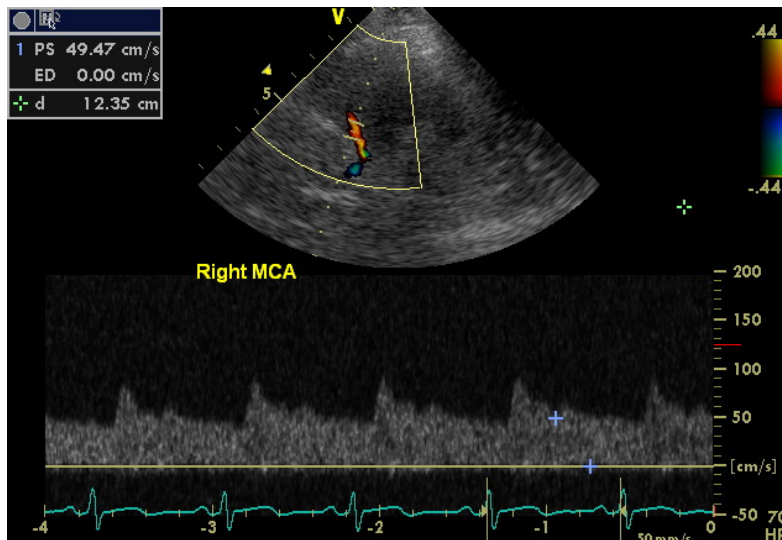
Doppler image of magnitude of flow in right MCA with 70 beats per minute.
